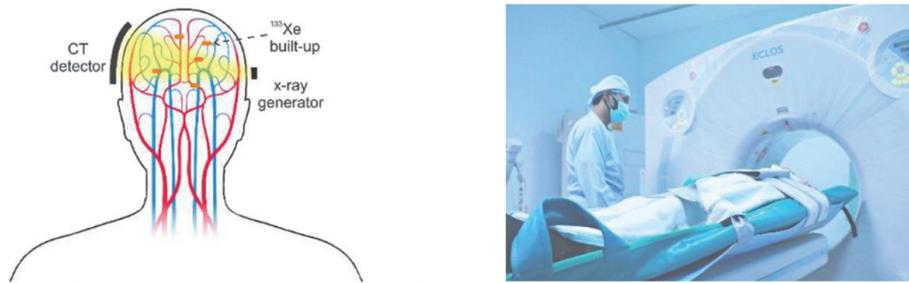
Xe-CT system contains a rotating X-ray source and an array of detectors that generate a tomographic image. The inhaled xenon gas can partly block X-ray and provide quantitative indicators for CBF measurement. High-resolution Xe-CT CBF imaging (see on the right) takes about 10 min [14].
